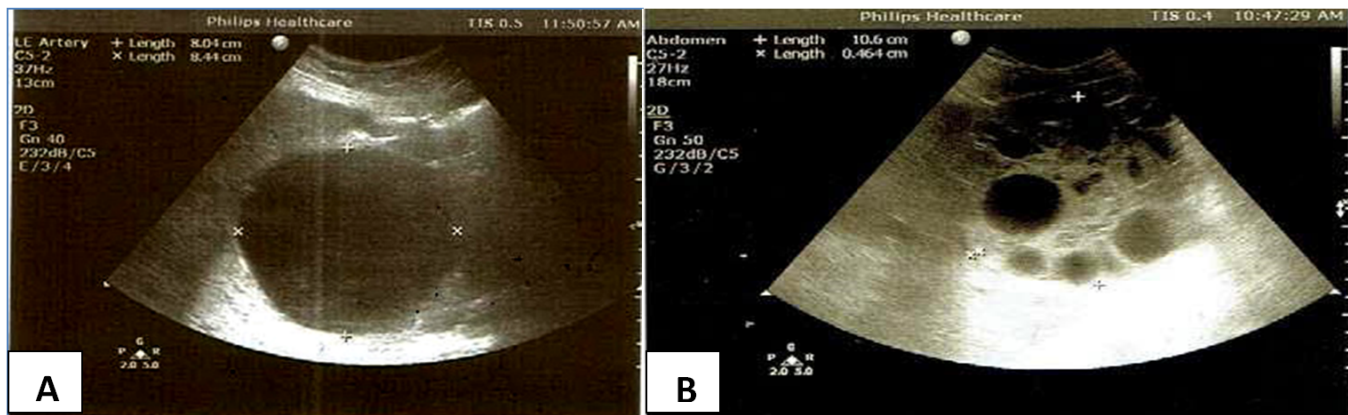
Liver ultrasound transverse scan showing A: unilocular type 1 HD CE1 with an echoic clear fluid content and smooth regular wall (active). B: multiple daughter cysts, plus multivesicular fluid CE2 (active).
